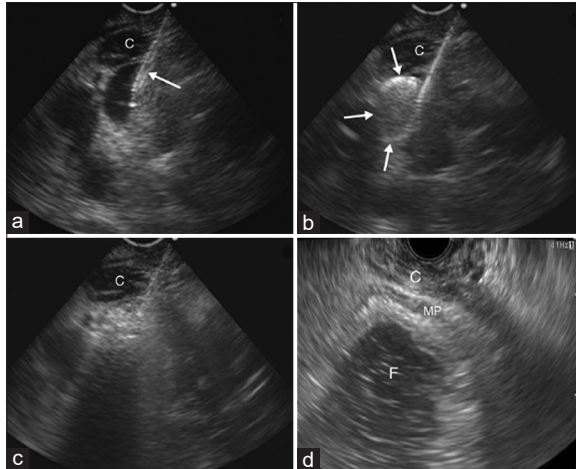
Endoscopic ultrasound-guided treatment of gastric varices with combined coiling and glue injection. (a) Transesophageal endoscopic ultrasound views (forward-view curved linear array endoscopic ultrasound) showing gastric varices targeted with a 19 gauge needle (arrow), (b) deployment of coil (arrows) through the 19 gauge needle, (c) injection of 1 mL glue through the 19 gauge needle to obliterate the gastric varice, and (d) eradication of gastric varices (conventional curved-linear endoscopic ultrasound). C: Crus muscle; F: Gastric fundus; MP: Muscularis propria of the gastric wall (reprinted from with permission from Elsevier)
